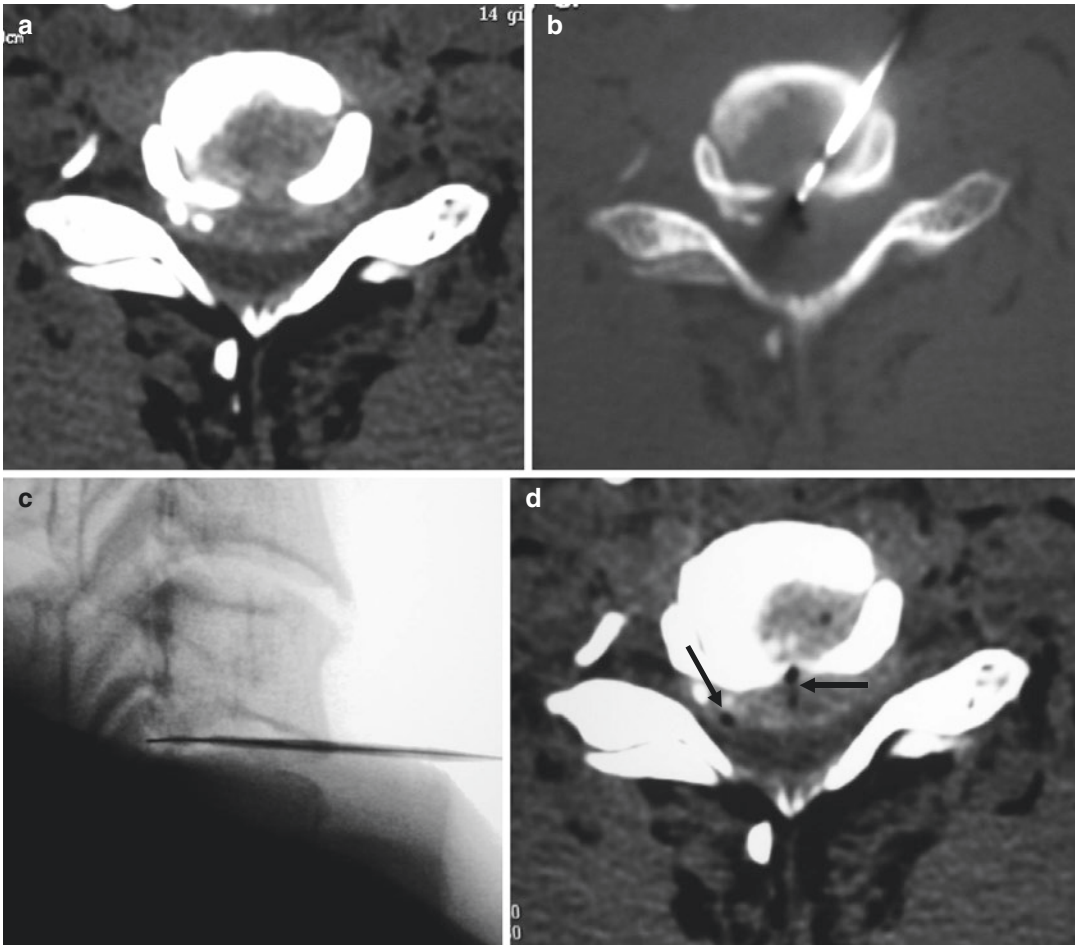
(a) Bilateral disk herniation at C6–C7 encroaching the spinal canal. The intervention was conducted under CT guidance for positioning the SpineWand device, switching to direct fluoroscopy during the ablation procedure. This allowed activation of the plasma-field energy
